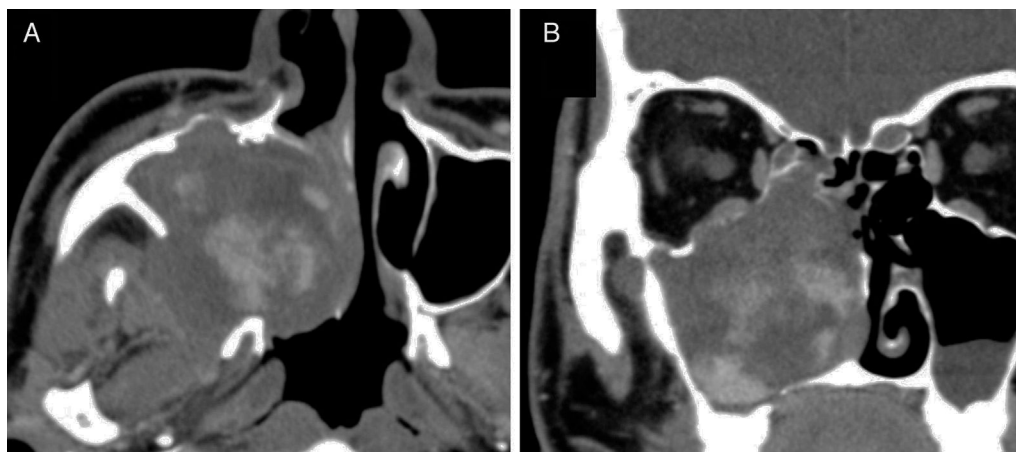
Enhanced CT in Case 1. Axial (A) and coronal (B) images. A strong, spreading, and gradually increasing contrast effect is seen during the arterial phase.
